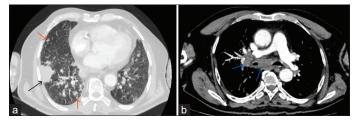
(a) CECT thorax in the lung window showing the peripheral mass lesion in the right lung (black arrow) with multiple bilateral parenchymal lung nodules (orange arrows); (b) CECT thorax in the mediastinal window showing subcarinal and right hilar lymphadenopathy (blue arrows). CECT: Contrast-enhanced computed tomography
